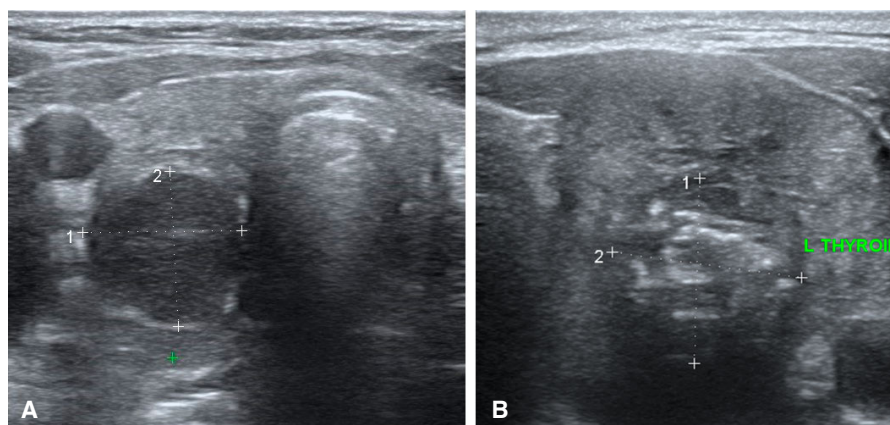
Ultrasound image showing examples of TIRADS 4B. (A) Solid and hypoechoic nodule, (B) solid with calcifications nodule.
